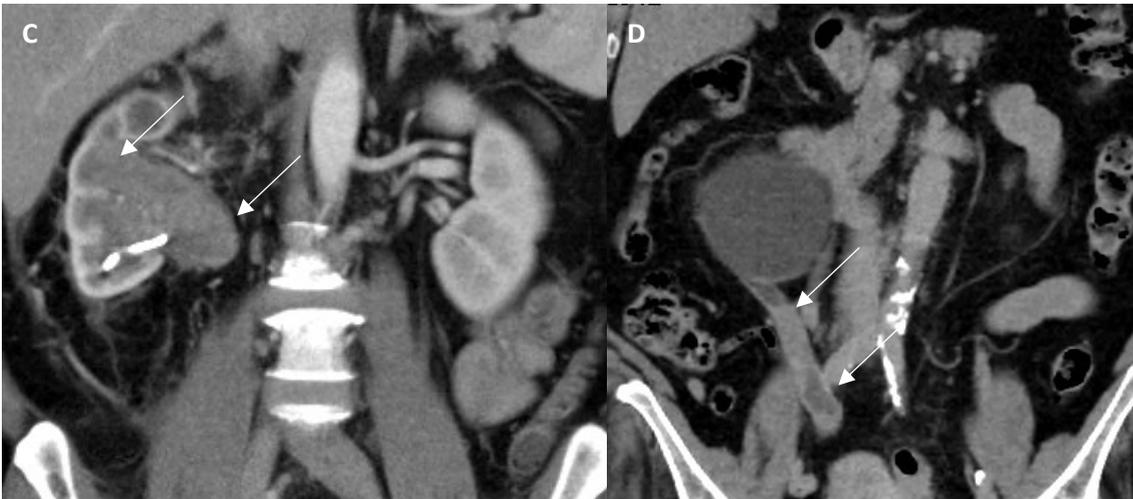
C - Contrast-enhanced CT – urotelial carcinoma of the renal pelvis (white arrows)
